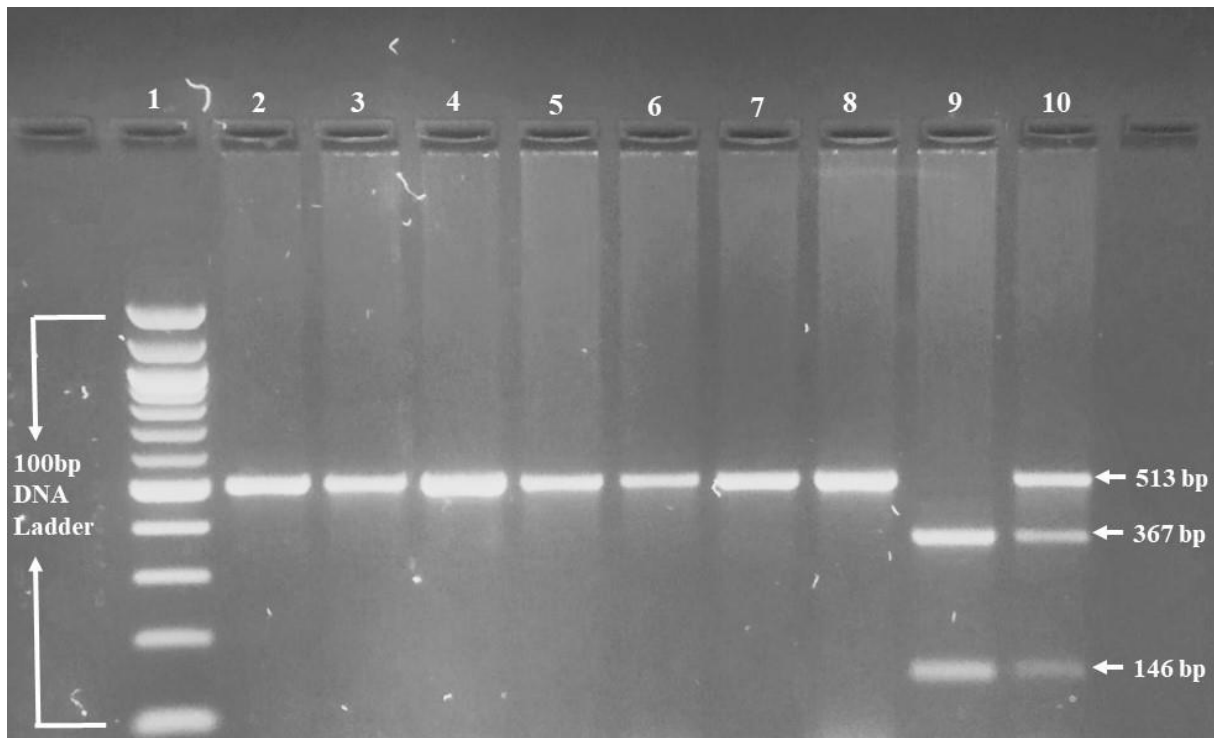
Restricted digested products of MTHFR C677T resolved in 1.5% agarose Gel. Lane 1 contains the 100 bp DNA ladder; lanes 2 to 8 represent the wild-type homozygotes (genotype CC). Lane 9 contains mutant homozygote (genotype TT). Lane 10 contains heterozygotes (genotype CT).
